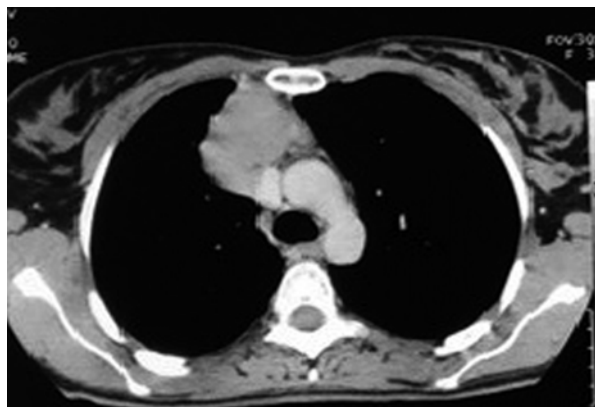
CT revealed anterior mediastinal mass
